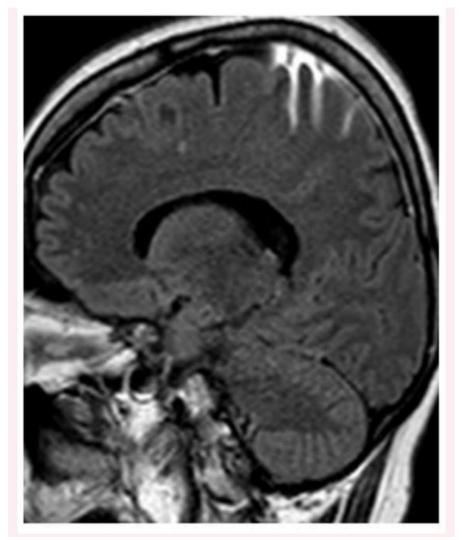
MRI Brain sagittal section Cerebral sagittal sinus thrombosis in our case.
